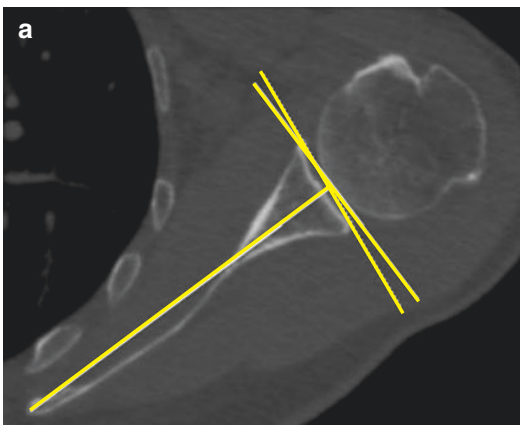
Glenoid version estimation: CT
